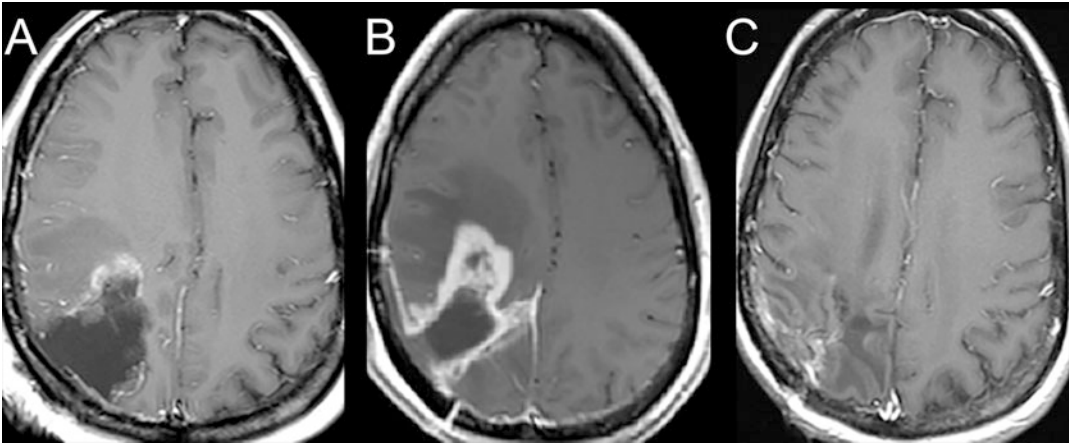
Pseudoprogression. Example of a 45-year-old female with GBM. Axial post-contrast images immediately after resection show minimal enhancing disease (a). Follow-up MRI at 1 month demonstrates new thick enhancement (b) that subsequently reduced on images 12 months out (c)
